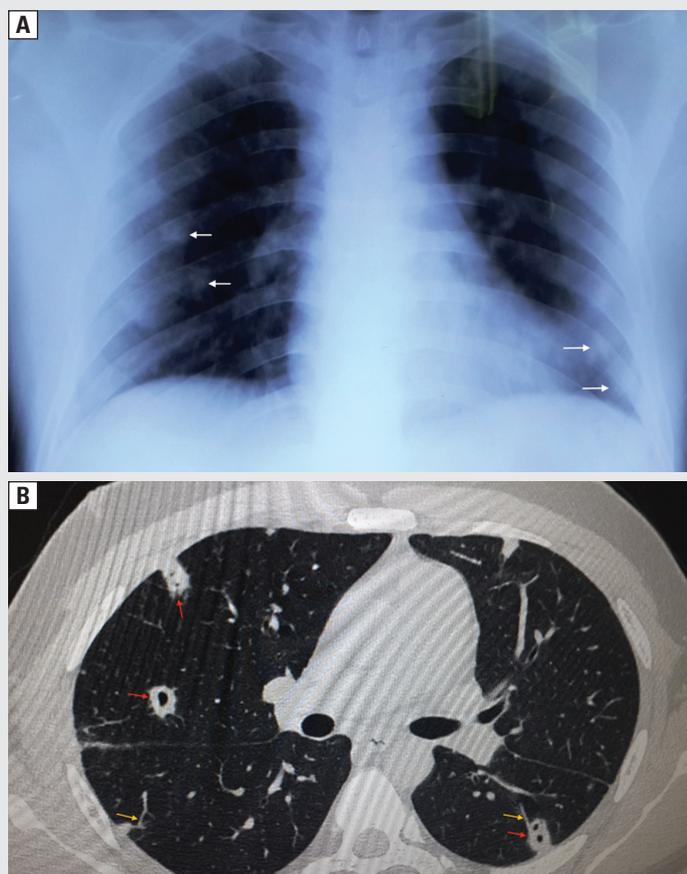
A. Chest radiograph (posteroanterior view) showing bilateral, ill-defined, nodular parenchymal opacities, mainly in mid and lower lung zones (white arrows). B. Chest computed tomogram scan (axial section, lung window) showing multiple, bilateral, peripheral parenchymal nodules, few showing cavitation (red arrows), and some having a distinct vessel branch directly entering the nodule — the feeding vessel sign (yellow arrows)
